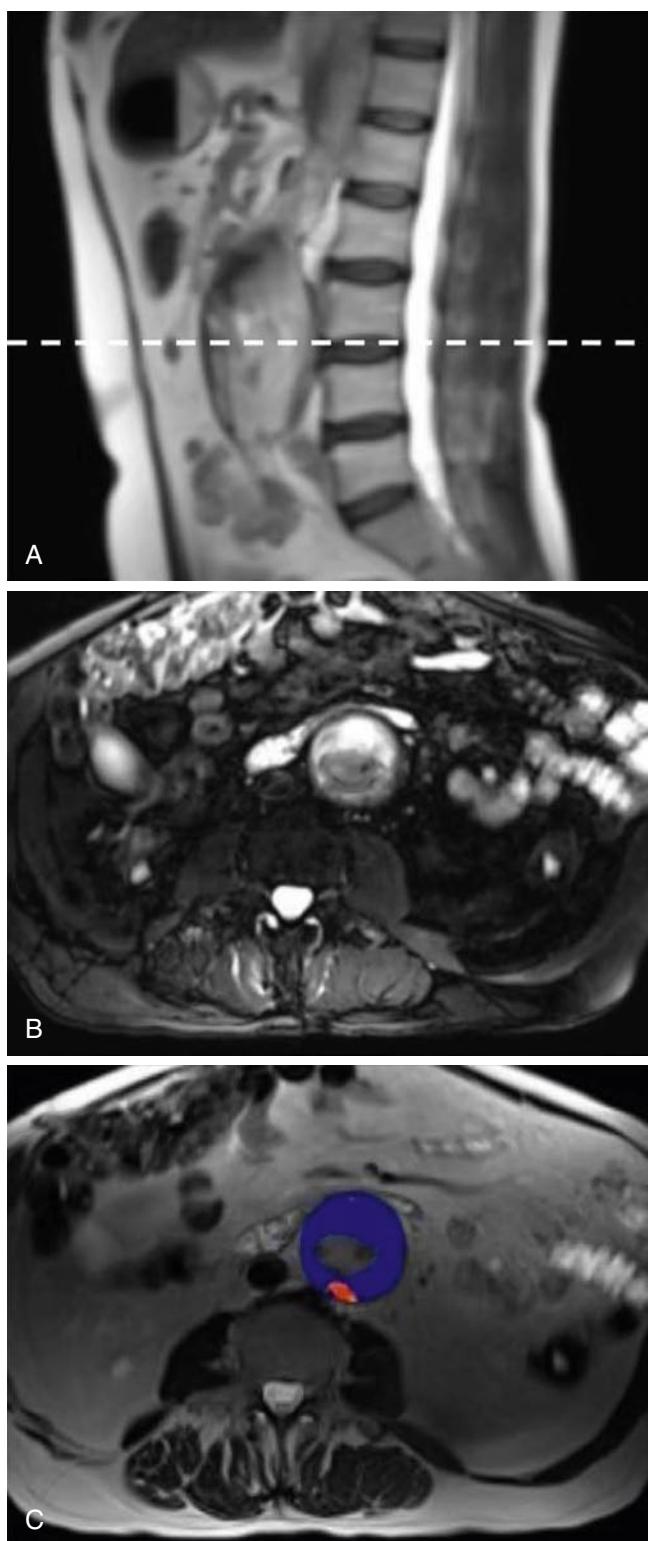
MRI of Abdominal Aortic Aneurysm. (A) T2-weighted HASTE (Half Fourier Acquisition Single Shot Turbo Spin Echo) sequence in the sagittal plane. (B) Cross-sectional image (dashed line in A) using a T2-weighted fat-saturated sequence to highlight intraluminal thrombus (white) within the aneurysm. (C) T2 map (blue) overlying the T2-weighted HASTE sequence (B), demonstrating enhancement of the posterior aneurysm wall with ultra-small super-paramagnetic particles of iron oxide (USPIO) (red). (From MA3RS Study Investigators, Newby D, Forsythe R, McBride O, et al. Aortic wall inflammation predicts abdominal aortic aneurysm expansion, rupture, and need for surgical repair. *Circulation.* 2017;136(9):787–797.)
